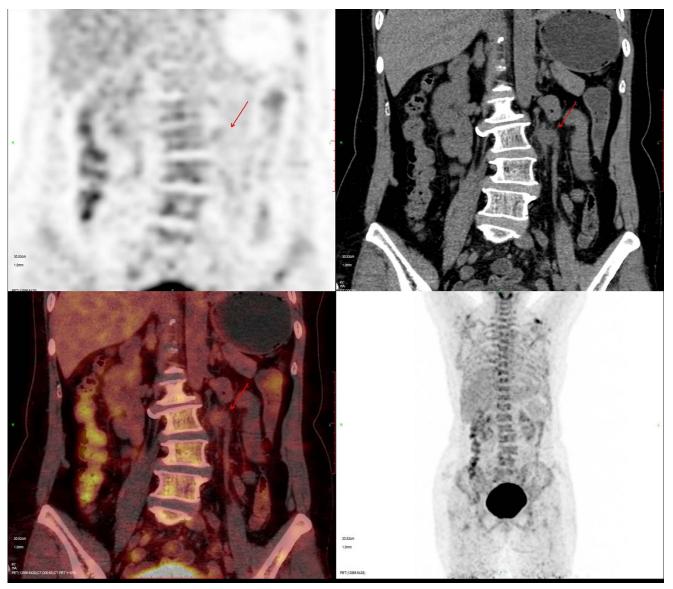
PET CT showed enlarged lymph nodes at the left renal hilum, increased glucose metabolism, slightly thickened intestinal anastomotic wall, and abnormal glucose metabolism.
